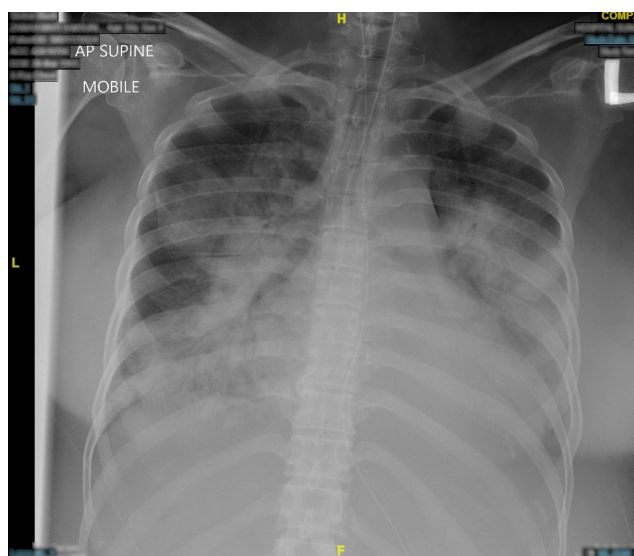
Chest radiograph taken on day of first intubation. Dense consolidations could be seen in middle and lower zones of bilateral lungs, relatively sparing bilateral upper zone.
